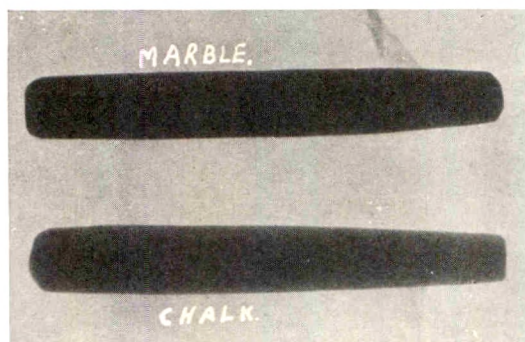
Roentgenogram of a piece of chalk and a
